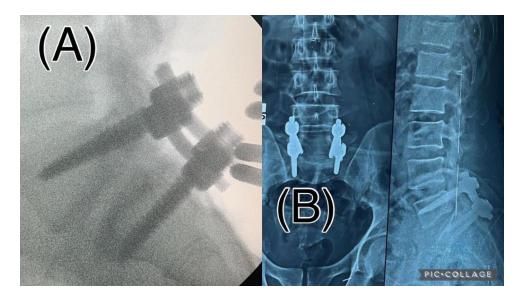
(A) immediately Postoperative x-rays demonstrating pedicle screw fixation with 4 screws and 2 plates Lateral view (B) 6 month Postoperative follow up x-rays demonstrating pedicle screw fixation with 4 screws and 2 plates and posterolateral
